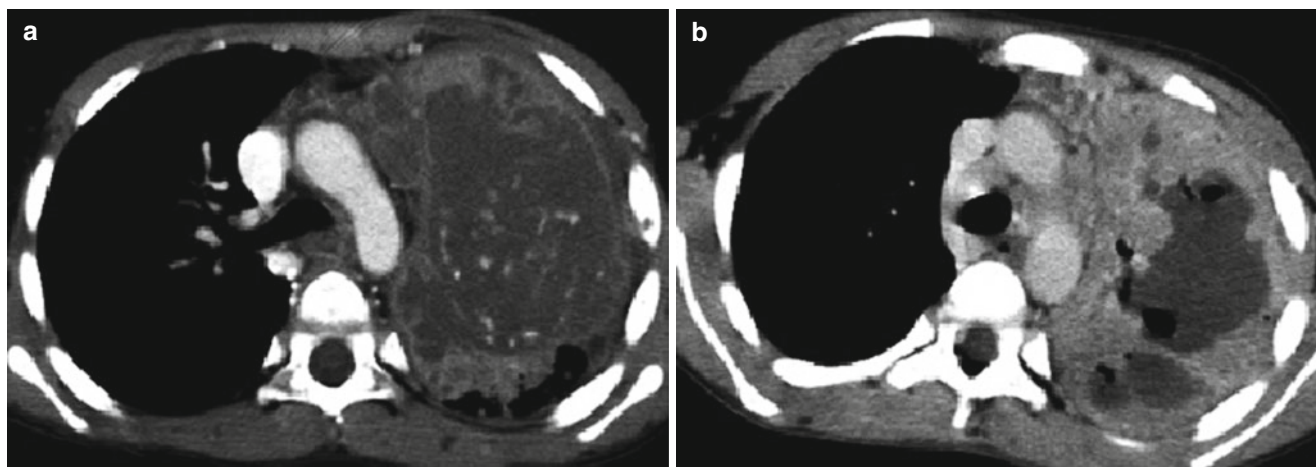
Progression of Ghon focus. CT scan images from two different patients showing advanced progression of lung parenchymal disease from dense consolidation with ischemic changes (a) and cavitary necrosis with cyst formation (b)
